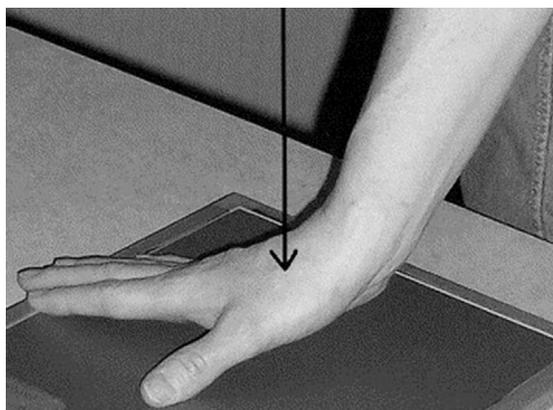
STT radiographic view. (From Wollstein R, Wandzy N, Mastella DJ, et al. A radiographic view of the scaphotrapezium-trapezoid joint. *J Hand Surg Am* 2005;30(6):1162; with permission.)
